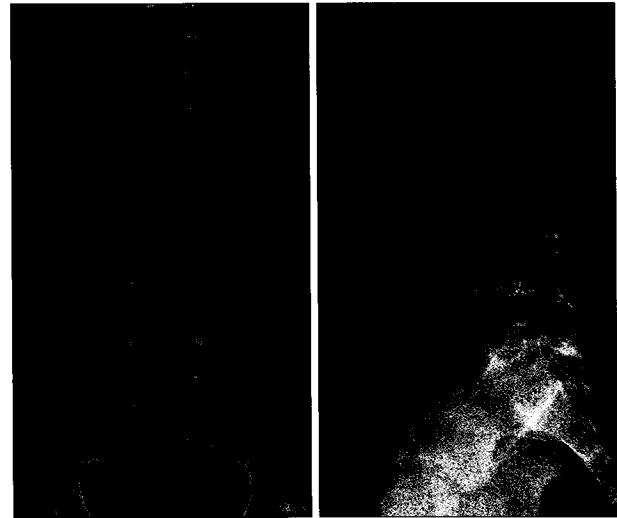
Simple radiographs showed the decreased lumbar lordosis as a result of muscular spasm and the antalgic posture of the patient.
